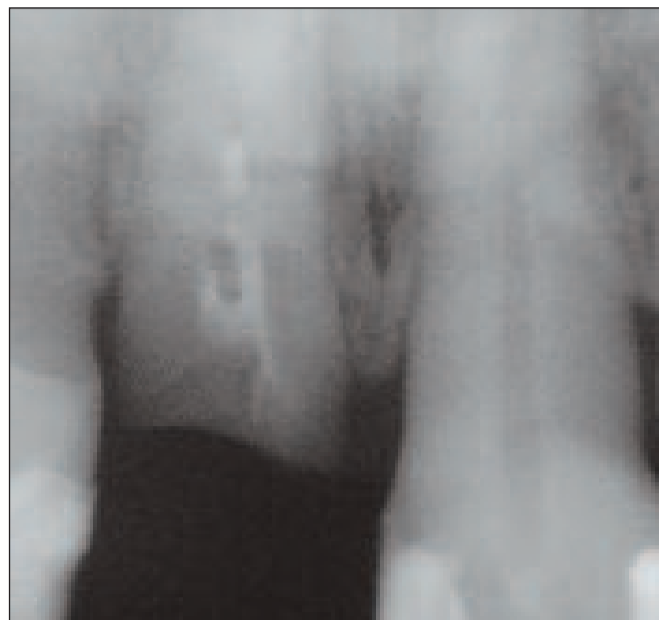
Radiograph Pre-op Fractured root UR1
